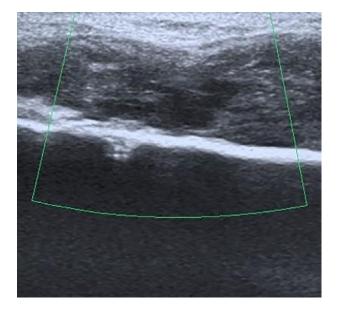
Ultrasound right clavicle with Doppler.
